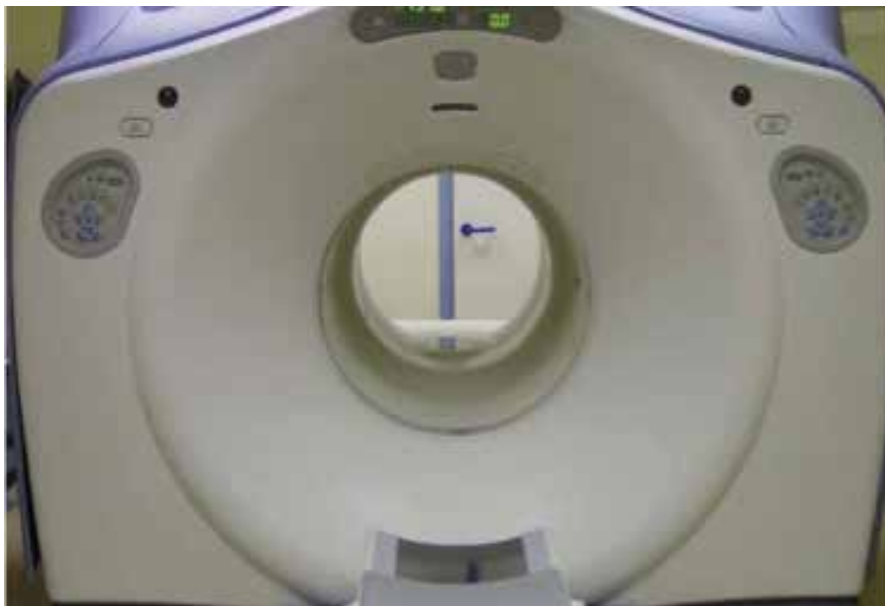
GE Discovery Lightspeed PET-CT
